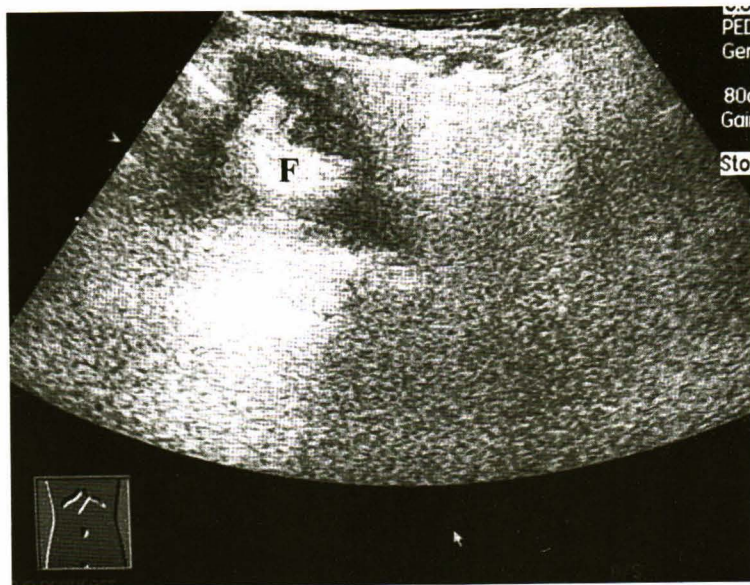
Cross sectional sonography of the mass showed hypoechoic mass with crescentic hyperechoic representing mesenteric fat inside (F). These findings are also characteristic for the intussusception.
